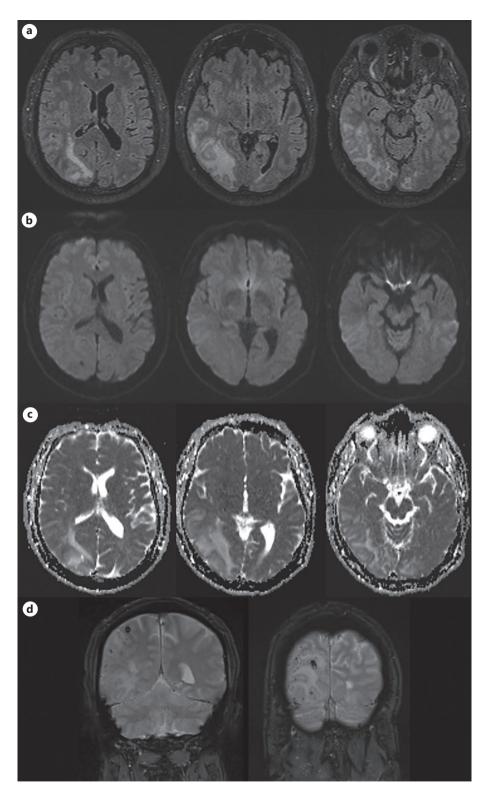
First brain MRI (on day 1, 25 October 2019) showing a vast vasogenic edema in the right parieto-temporo-occipital region, and to a lesser degree the left occipital region, and several right parieto-temporo-occipital petechial lesions (confluent hyperintensities on FLAIR (a); no restriction of signal in diffusion (b); hyperintense signal on apparent diffusion coefficient (c); petechial lesions in gradient echo sequence (d)).
